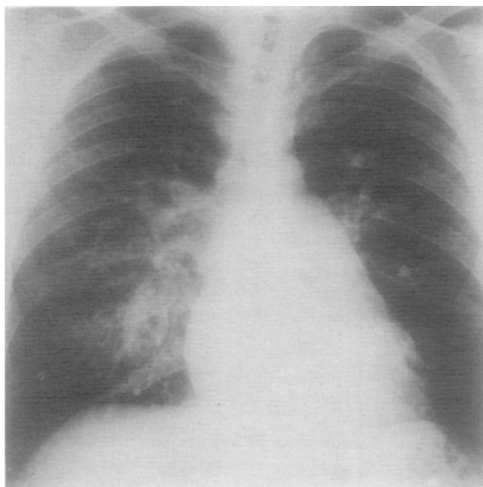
Case 1. Chest roentgenogram. Increased pulmonary vasculature mainly confined to right side.
